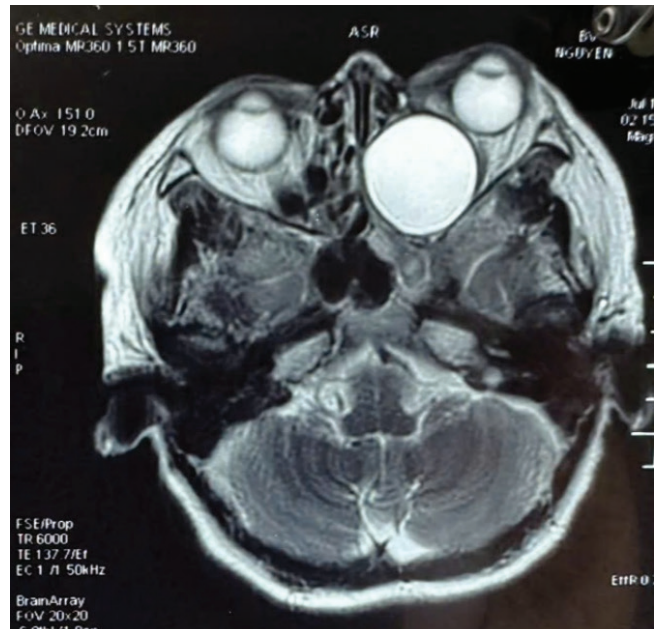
Axial MR imaging of the paranasal sinus and orbital globe with T2WI demonstrating an ethmoid mucocoele causing mass effect to the left orbital globe.
